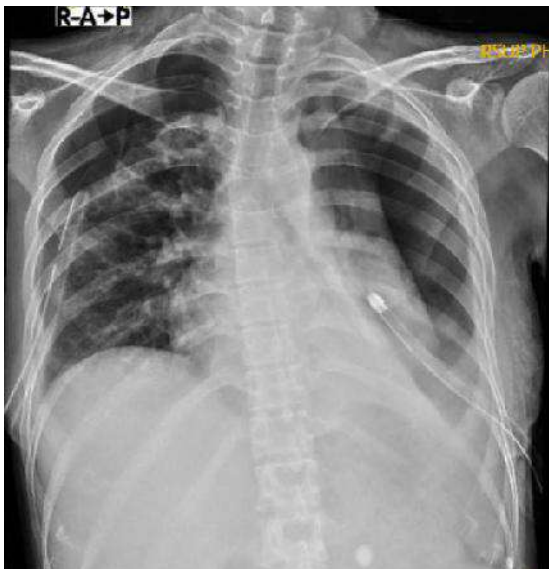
Thoracic x-ray on November 26, 2023
